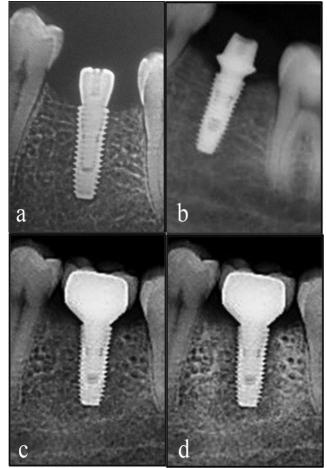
Periapical x-ray of the implant (early loading) throughout the follow up period. (a) immediately postoperatively. (b) 1^{st} month postoperatively. (c) 3^{rd} month postoperatively. (d) 6^{th} month postoperatively.
